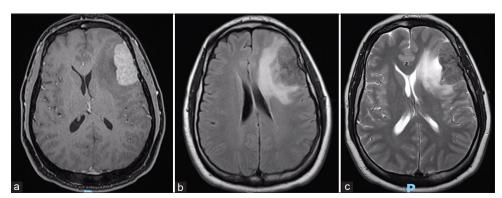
Magnetic resonance imaging showing expansive lesion in the left frontal region with left to right mass effect and surrounding edema. (a) Axial gadolinium-enhanced image. (b) Axial FLAIR. (c) Axial T2-weighted.
